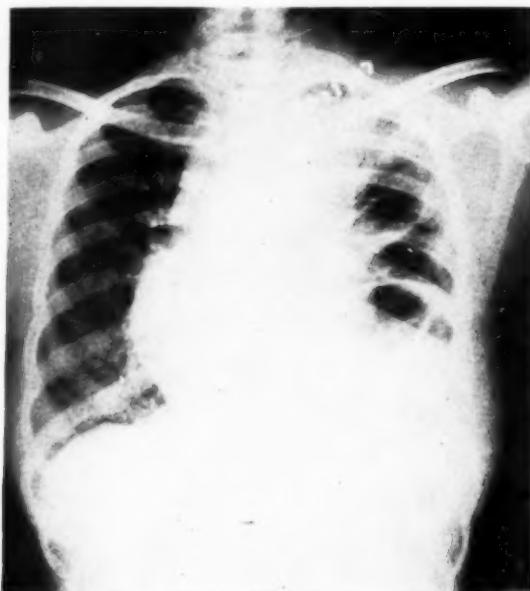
Case 1. Roentgenogram of chest on Dec. 23, 1948. Discussed in text.
